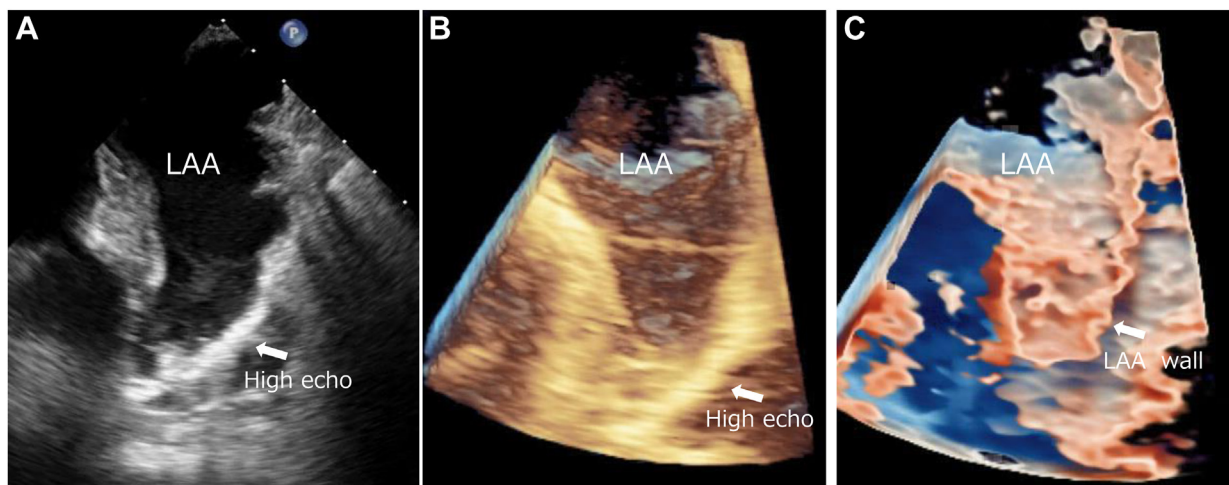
Representative example of two-dimensional (A), three-dimensional volumetric (B), and photorealistic three-dimensional rendering (C) upper esophageal transesophageal echocardiographic images of the LAA. The high echoic partition is seen in both A and B, but there is a clearly defined border of the LAA wall without high echoic partition in C.
